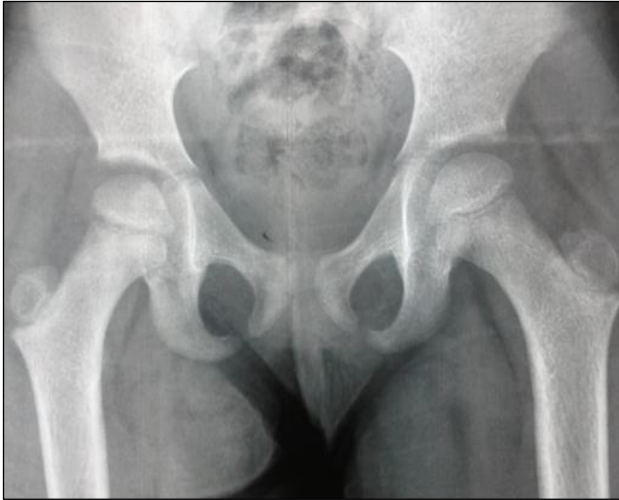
X-ray of both hips at 6 months follow up.
